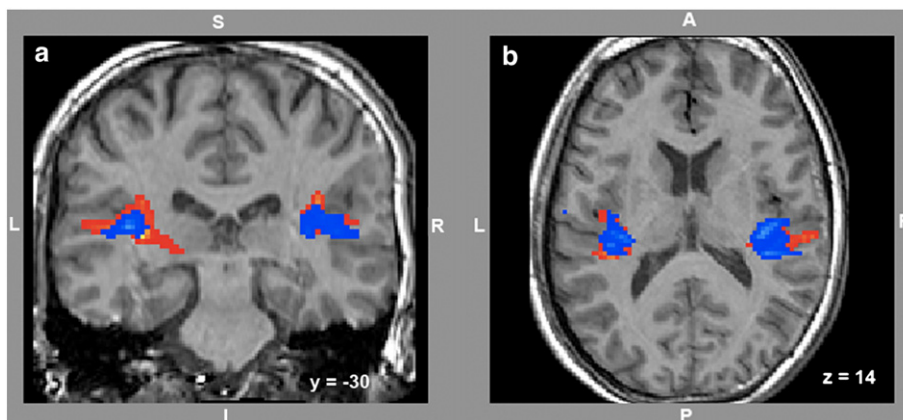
Probabilistic fibre tractographs of the synaesthete E.S. (red-yellow) and the average tractographs of the 10 professional musicians with absolute pitch (blue-lightblue). We used a multiple regions of interest (ROI) approach to invoke tractography. ROIs were placed bilaterally in the insula, the Heschl's gyrus, and the planum temporale, hence only tracts that pass through all three ROIs were retained. Panel a shows the coronal slice with the largest tractographic difference in the left–right direction in the left tractograph. Panel b shows the transversal slice with the largest tract difference in the left–right direction in the right tractograph. Tractographs are superimposed on the structural MR image of the synaesthete E.S.
